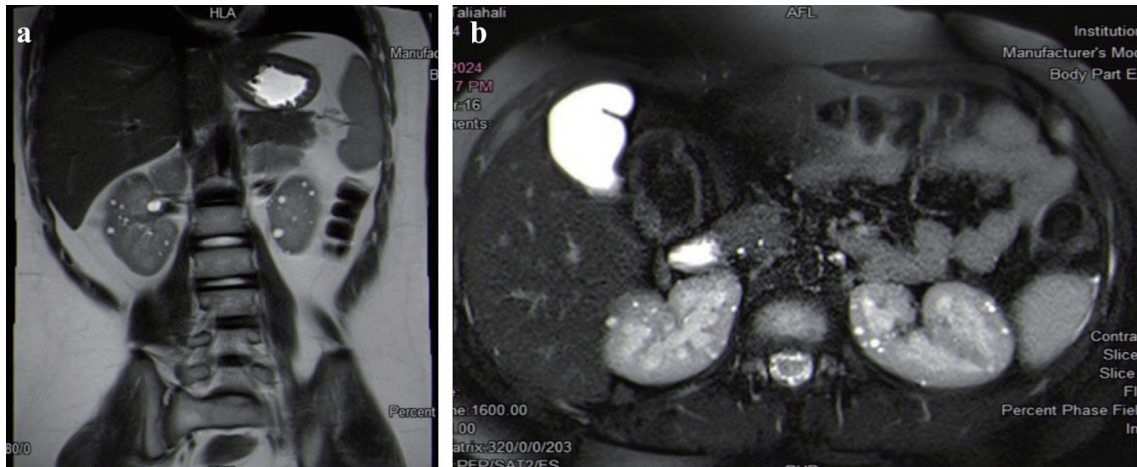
(a, b) Kidney MRI shows multiple innumerable renal cysts, the largest measuring 0.8 cm. A well-defined round cortical lesion is noted in the interpolar region of the right kidney, which is concerning for renal cell carcinoma. MRI: magnetic resonance imaging.
